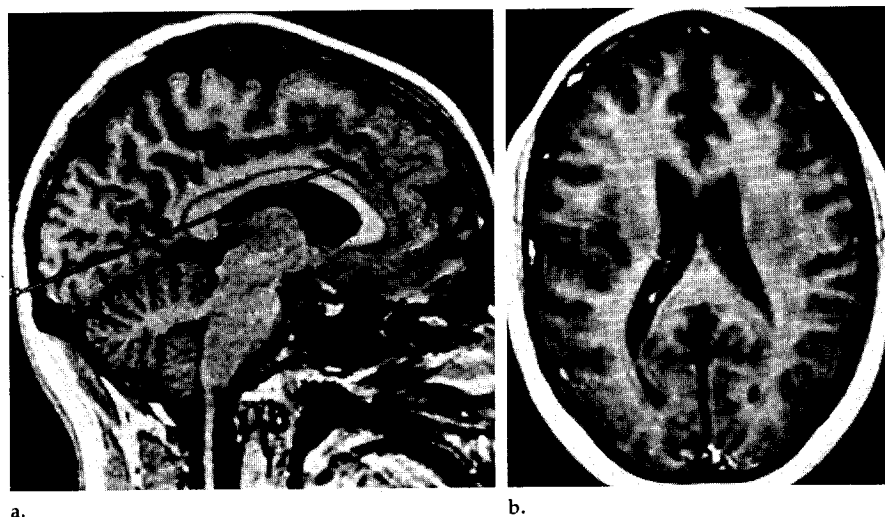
Subject 4. (a) Midsagittal localizer image. A line is drawn along the calcarine fissure. (b) Oblique high-resolution T1-weighted anatomic image obtained in a plane aligned along the calcarine fissure.
